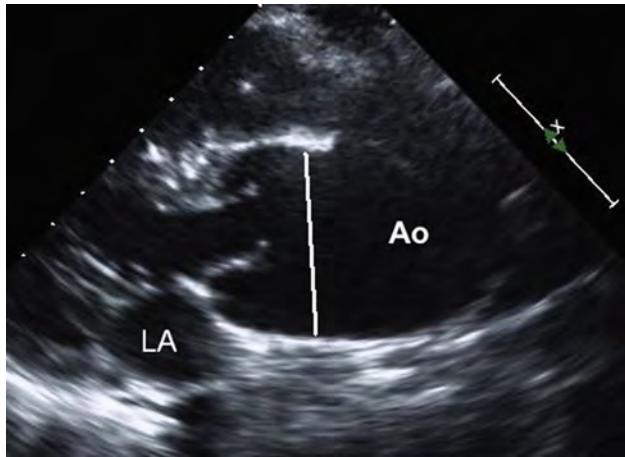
Parasternal long-axis view of a dilated neo-aortic root in an adolescent patient after the ASO. Note the lack of the normal ST junction and the relatively normal size of the valve annulus in comparison with the root. The neo-aortic root is measured inner edge to inner edge as per typical pediatric method. Ao, Aorta; LA, left atrium.
